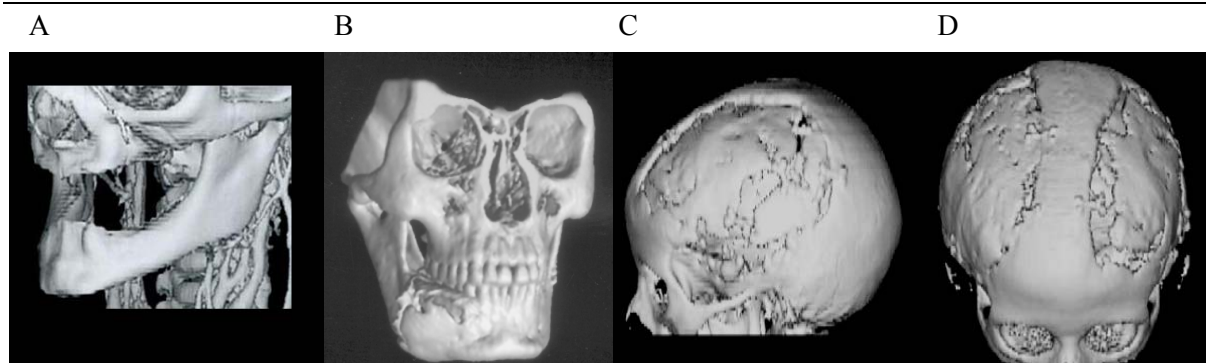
depicts different causes of bone defects. (A) Underdeveloped jaws in ectodermal dysplasia, a congenital disease characterized by poorly developed alveolar processes as if they were old and atrophic and missing teeth. (B) Ameloblastoma of the right mandible. (C,D) Craniofacial traumatism after a fall. 3D computed tomography (CT) images. (Larheim TA et al. Maxillofacial imaging. Ed. Springer. 2008). (Alam A et al. MJAFI. 2005). (Lendeckel S et al. J Craniomaxillofac Surg. 2004).
